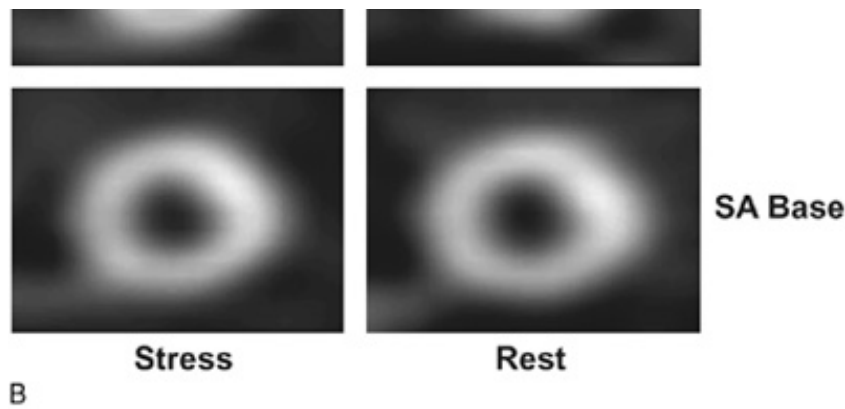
Short-axis views. A. Collage of anatomic sections obtained by "bread slicing" the heart in its short-axis plane, corresponding to the tomographic sections obtained by echocardiography and SPECT imaging, viewed from the apex toward the base of the heart. B. Comparable sestamibi SPECT images of the left ventricle showing normal myocardial perfusion at rest and with exercise. SA, short axis.
